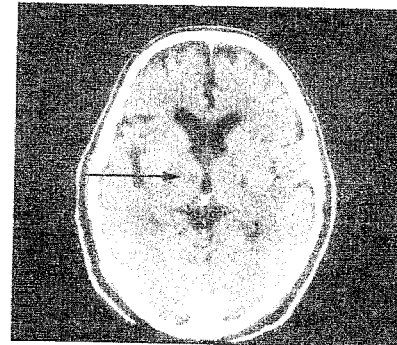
Horizontal computed axial tomography scan (top) showing infarction in left thalamus. Coronal magnetic resonance image (bottom) demonstrating subacute cerebellar infarct, as well as moderate atrophy. (Courtesy Eric Zillmer.)
